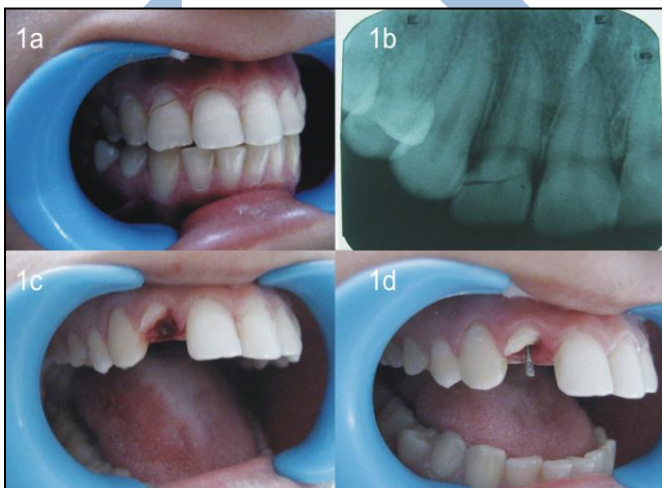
Photograph showing fracture maxillary lateral incisor. 1b. Radiograph showing fracture line in maxillary lateral incisor. 1c. Clinical view after the removal of the fractured fragment. 1d. Post positioning to accommodate the fracture fragment.
